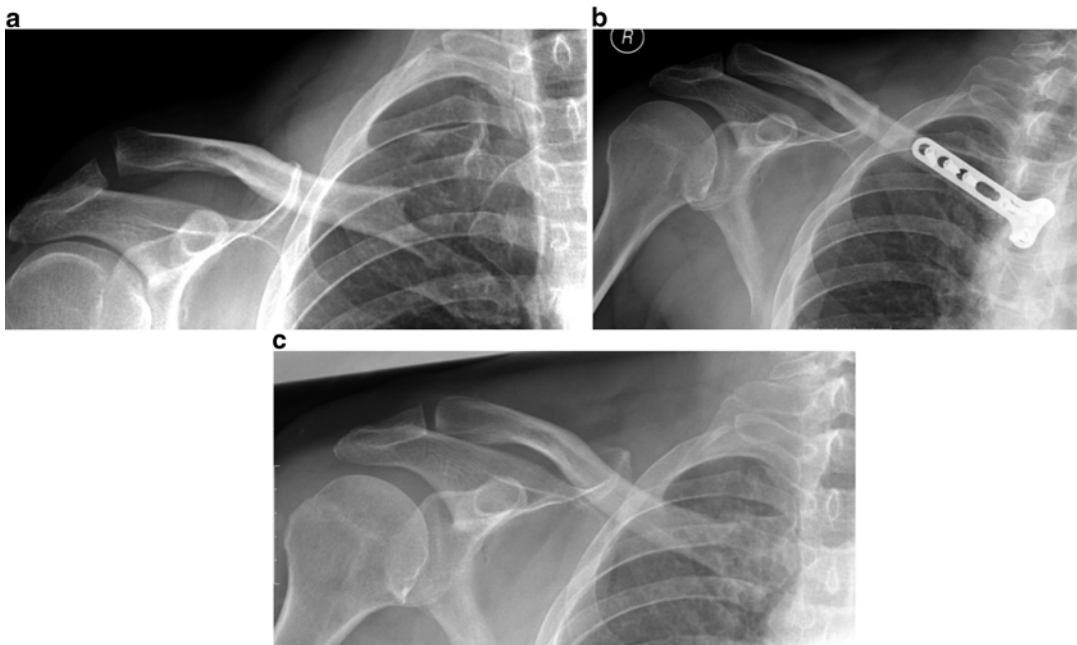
Example of locking plate fixation of a medial third clavicle fracture dislocation injury (a), postfixation (b), and healed following hardware removal (c) anteroposterior X-rays
